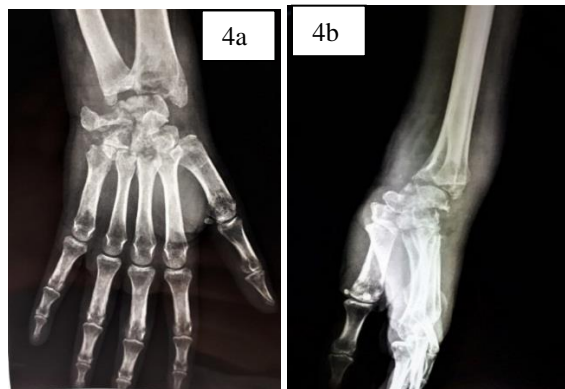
Showing- X-ray of healed tuberculosis of wrist
